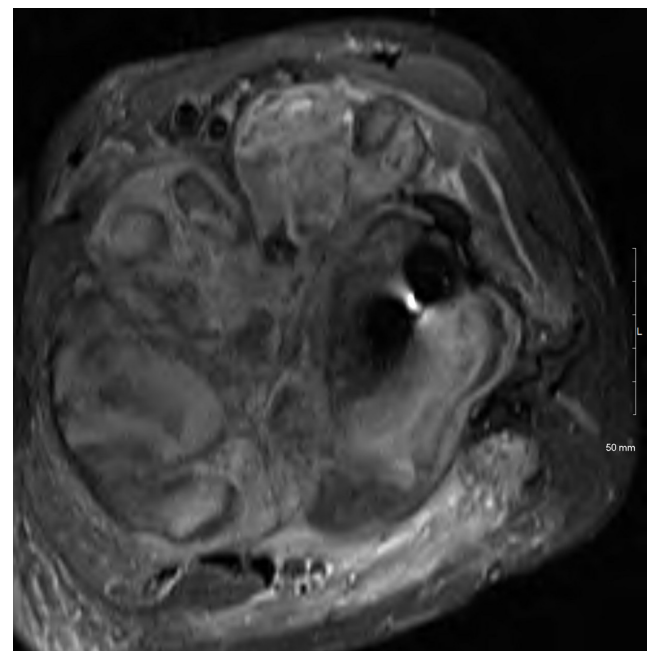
MRI (fat suppressed) of the left proximal femur, axial
